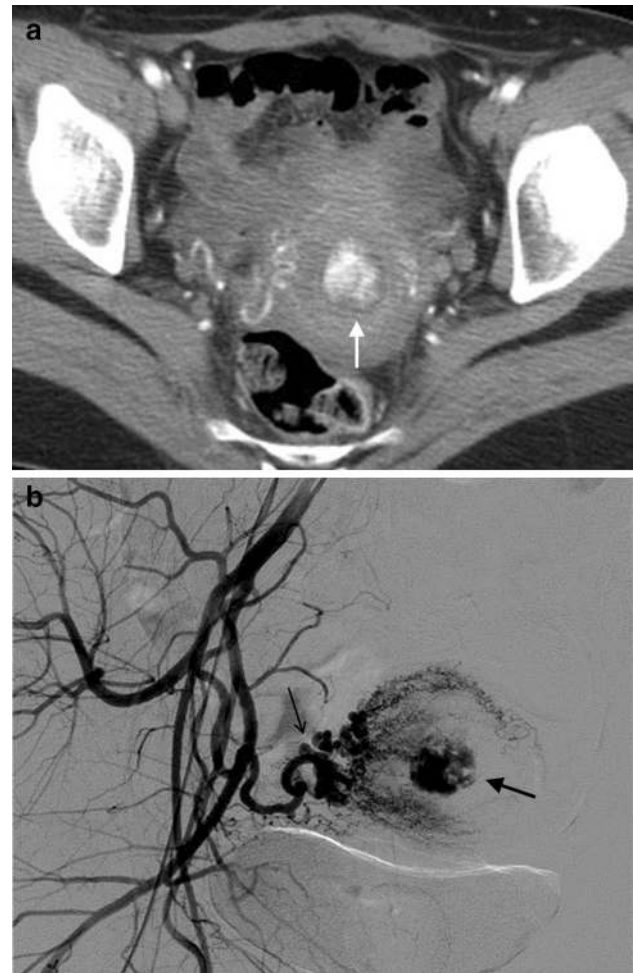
25-year-old woman with genital bleeding 1 month after a normal vaginal delivery. Ultrasound showed an echogenic mass in the endometrial cavity at the lower uterine segment (not shown). a Contrast-enhanced CT during the arterial phase shows a markedly enhancing mass (arrow) in the uterine cavity. b Right internal arteriography shows a dilated right uterine artery (small arrow) and a hypervascular mass (arrow) corresponding to the uterine cavity. Uterine artery embolization and subsequent hysteroscopic resection were performed, confirming the diagnosis of retained products of conception
